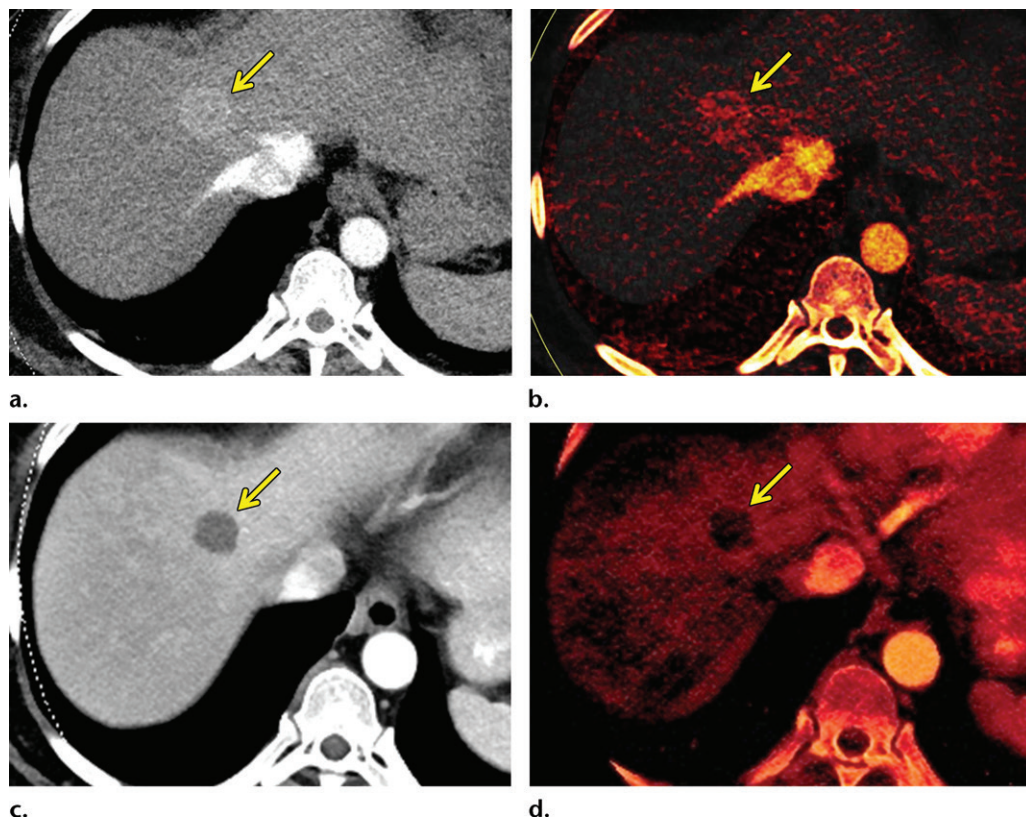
Decrease in enhancement and iodine concentration in a hepatic metastasis of RCC in a 58-year-old woman after treatment with a tyrosine kinase inhibitor. (a) Baseline contrast-enhanced CT image of the upper abdomen obtained during the early arterial phase shows an avidly enhancing lesion in the right hepatic lobe (arrow), which is compatible with an RCC metastasis. (b) Contrast-enhanced CT image acquired after the initiation of pazopanib shows a decrease in enhancement in the hepatic lesion without a substantial change in size (arrow). (c, d) Iodine maps obtained before (c) and after (d) therapy show a corresponding decrease in iodine concentration (arrow).
